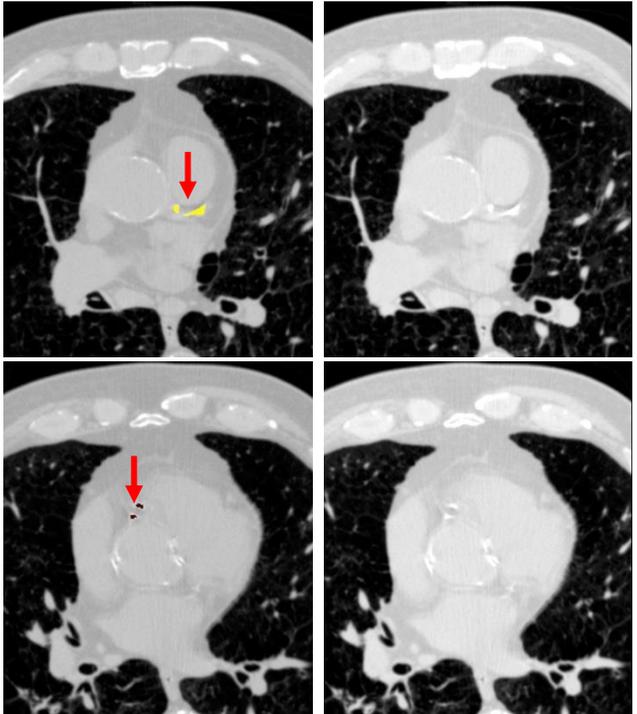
Color-coded overlay of detected calcifications (left). Original chest CT scan (right).
